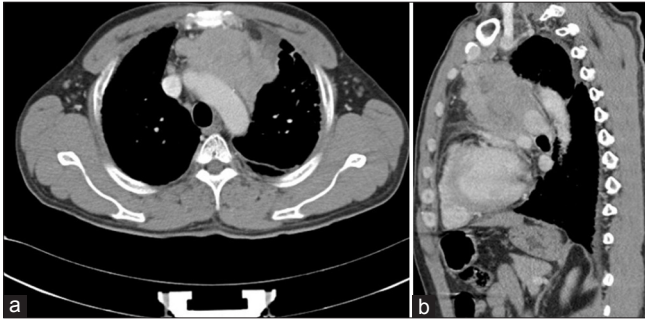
(a) CT scan of the thorax showing non-homogenous mass in the anterior mediastinum with necrosis. (b) Coronal section of the CT scan thorax showing the non-homogenous mass in the anterior mediastinum
